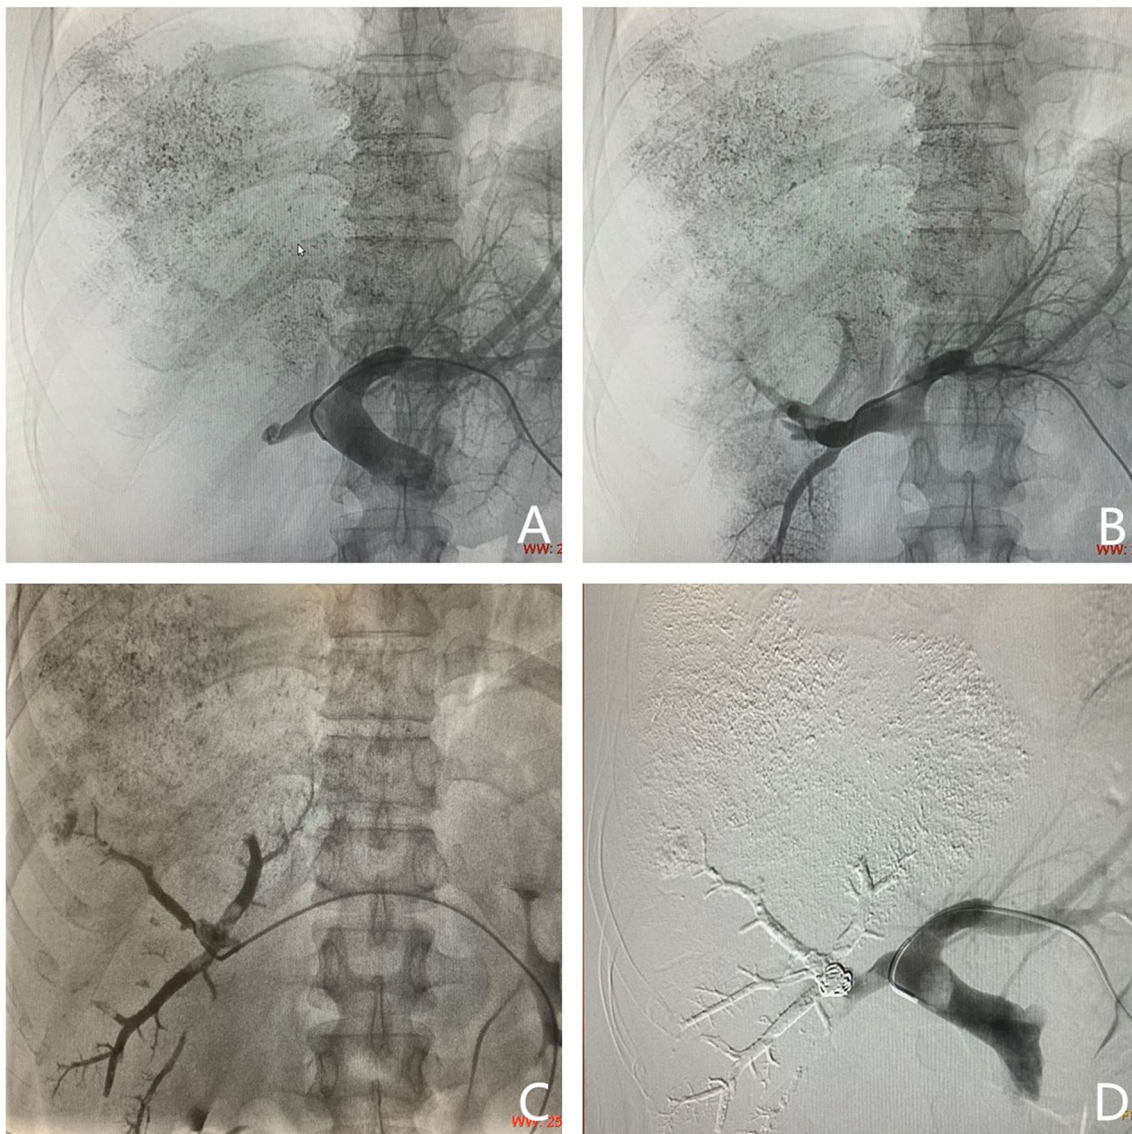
Images of portal vein embolization performed in a 44-year-old man (same patient as in Figure 1). Puncturing a suitable branch of the portal vein with the guidance of ultrasound. (A) Portography with a catheter placed into the main portal vein. The right portal vein is not completely visible; it appears as a thrombosis in the right portal vein and matched the images acquired by magnetic resonance imaging. (B) Portography with a catheter placed into the right portal vein. (C) Image showing embolizing of the targeted portal vein. (D) Portography after embolizing of the right portal vein. The targeted portal vein was embolized using an NBCA/Lipiodol mixture and coils.
